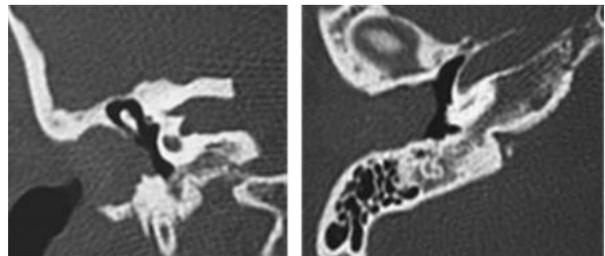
(a) coronal cut CT scan of the right temporal showed a large cholesteatoma filling the external auditory canal and eroding its superior and inferior walls. (b) axial-cut temporal CT scan in the same patient showed expansion of mass and pushes the tympanic tube into the middle ear space
